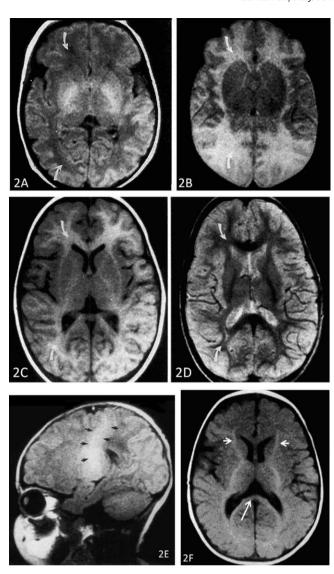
Axial T1-weighted (A and C) and T2-weighted (B and D) images obtained at the level of the basal ganglia. The white matter (curved arrows) of a neonate (A and B) has a low signal intensity compared to gray matter in a T1 weighted image (A) but a higher signal intensity in a T2-weighted image (B). The reverse appearance occurs in a 14-month-old infant (C and D), showing progress toward an 'early adult' stage. In T2-weighted images, high-signal intensity unmyelinated white matter progressively changes to a signal intensity lower in myelinated white matter than that in gray matter (after Ballesteros et al., 1993). (E) Parasagittal T1-weighted image of a 1-month-old infant showing hyperintensity in the central white matter adjacent to the Rolandic fissure as myelination extends upward from the posterior limb of the internal capsule (arrows) (after Ballesteros et al., 1993). (F) Axial T1 weighted image of a 5-month-old infant. The splenium of the corpus callosum is myelinated (long arrow). Myelinated nerve fibers extend more rostrally in the anterior limb of the internal capsule (short arrows).
